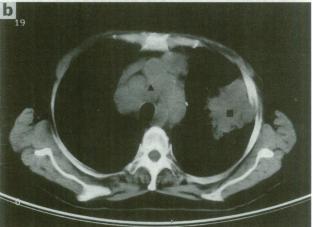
a, Positive axial SPECT scan of the thorax of a patient with midline mediastinal nodes from small-cell lung cancer. The squares over the tumour and over the normal tissues posteriorly over the midline represent the regions of interest (ROI). b, Computerised tomography scan of the thorax demonstrating the anterior mediastinal mass corresponding to the increased uptake on the SPECT IAZA scan on the same patient. ▲ mediastinal small-cell lung cancer. ■, post-obstructive pneumonitis.
